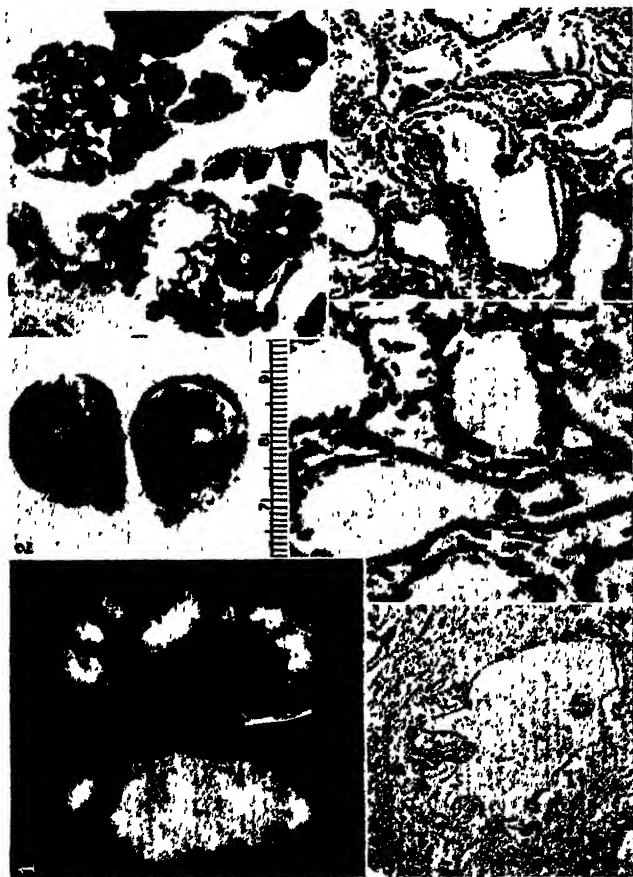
Hyperparathyroid renal disease. 1. X-ray of kidneys in a case of hyperparathyroidism, showing massive deposits of calcium. 2. Parathyroid adenoma in this case, as seen from the external and cut surface. The dark area on the cut surface is a region of hemorrhage (scale in centimeters). 3, 4, 5, and 6. Interstitial and paratubular calcium deposits in the kidney. (From *Endocrinology* 24: 372, 1939.)
